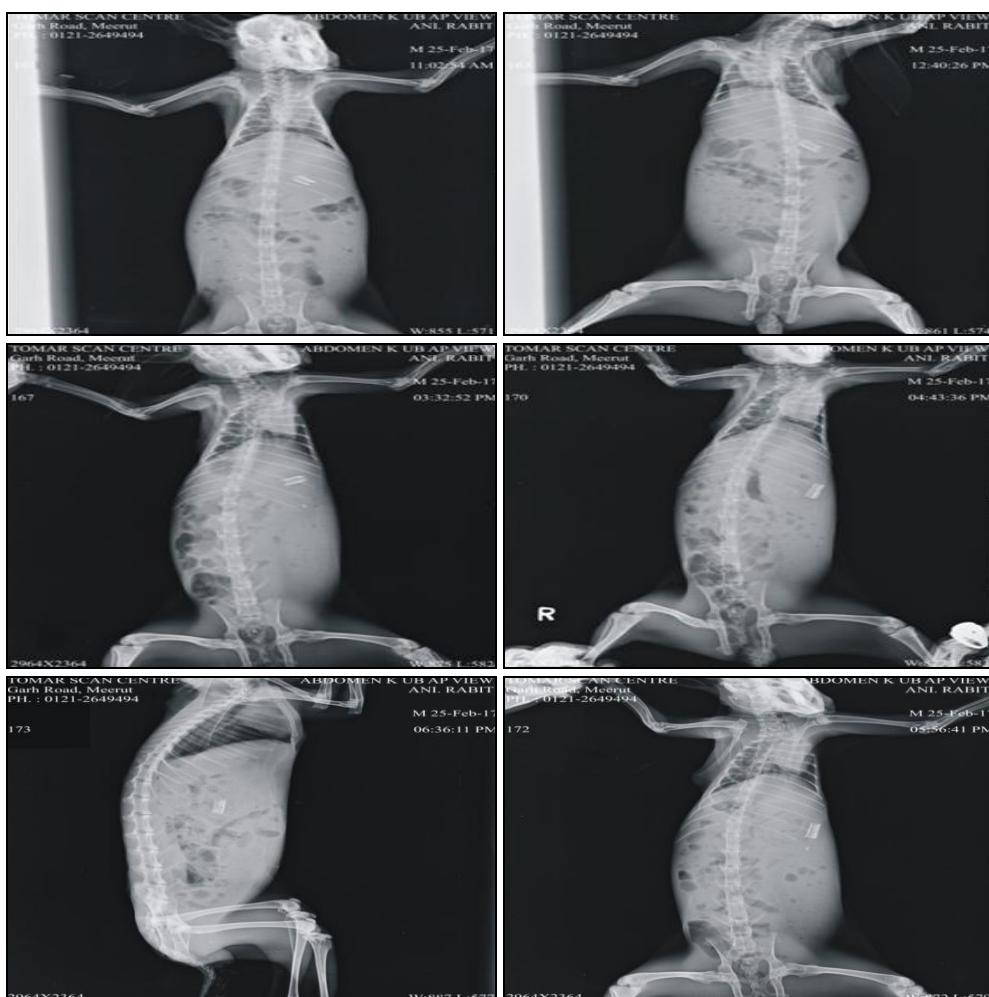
RADIOGRAPHIC IMAGES SHOWING THE PRESENCE OF BaSO₄ LOADED FLOATING TABLET IN THE STOMACH AT 0, 2, 4, 6, 8, 10 h
